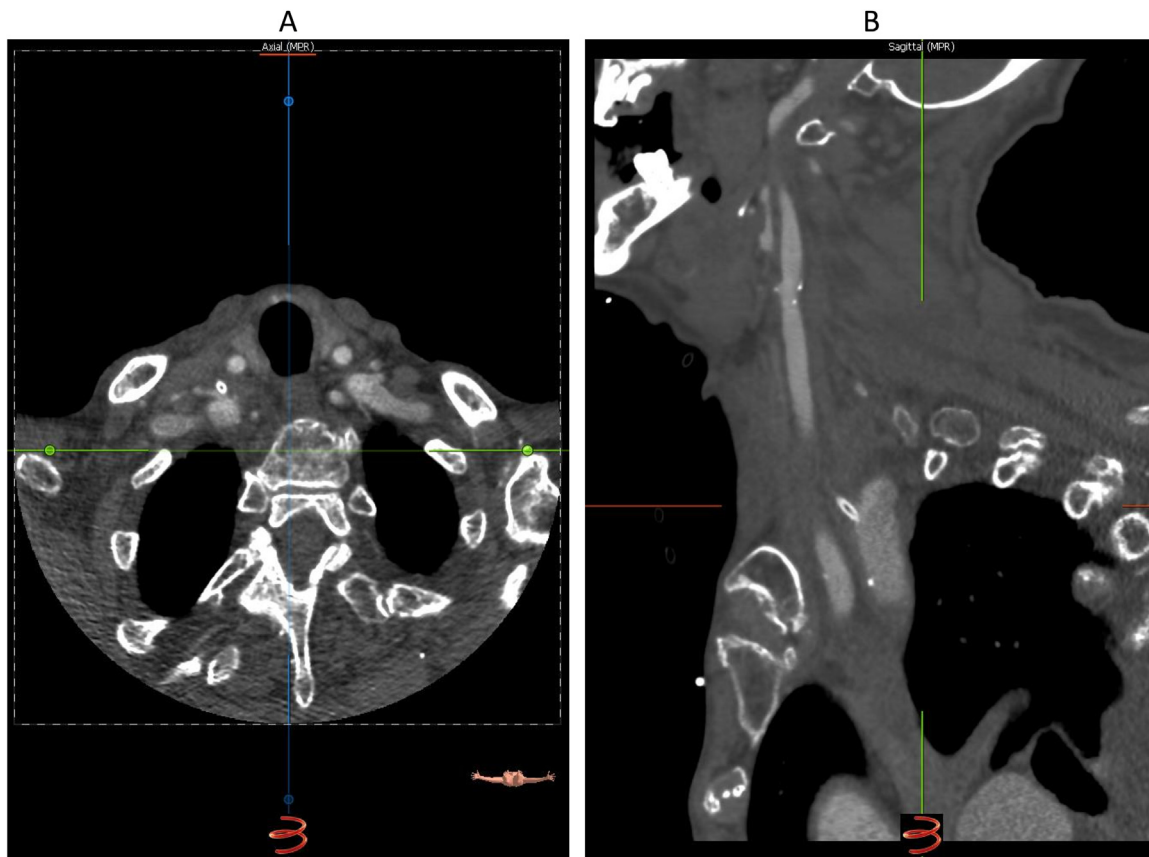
Computed tomography angiography of the neck in axial window (A) and in sagittal slice (B) with evidence of right subclavian artery central line, resulting in iatrogenic injury.
